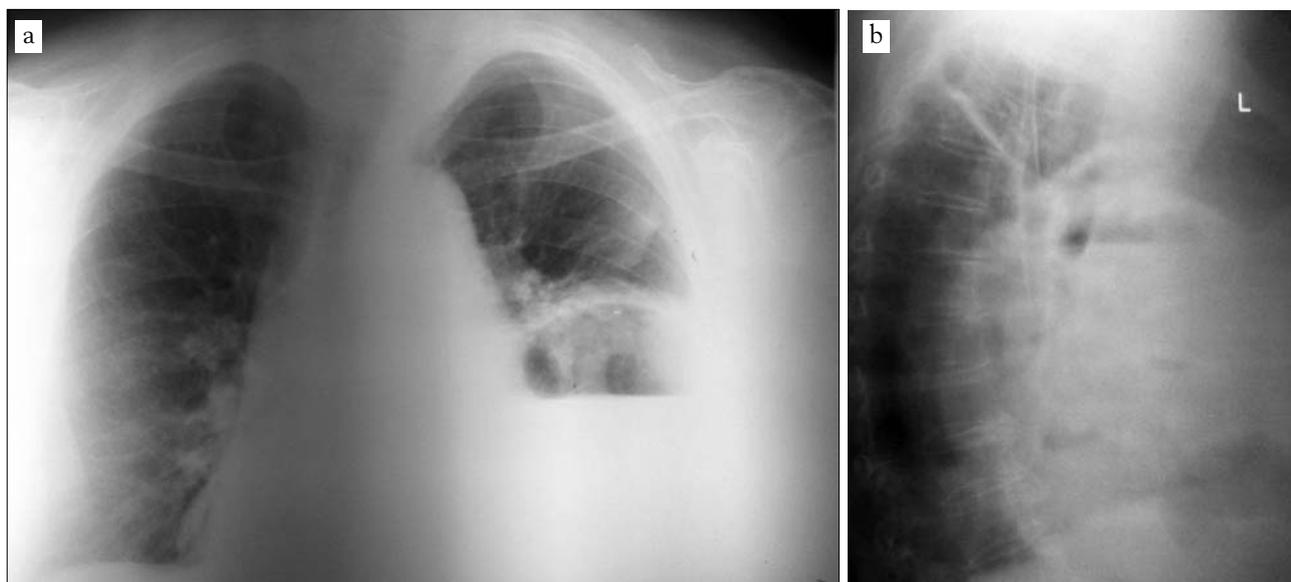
(a,b) Frontal and lateral chest X-Ray - large opacity with air-fluid level
